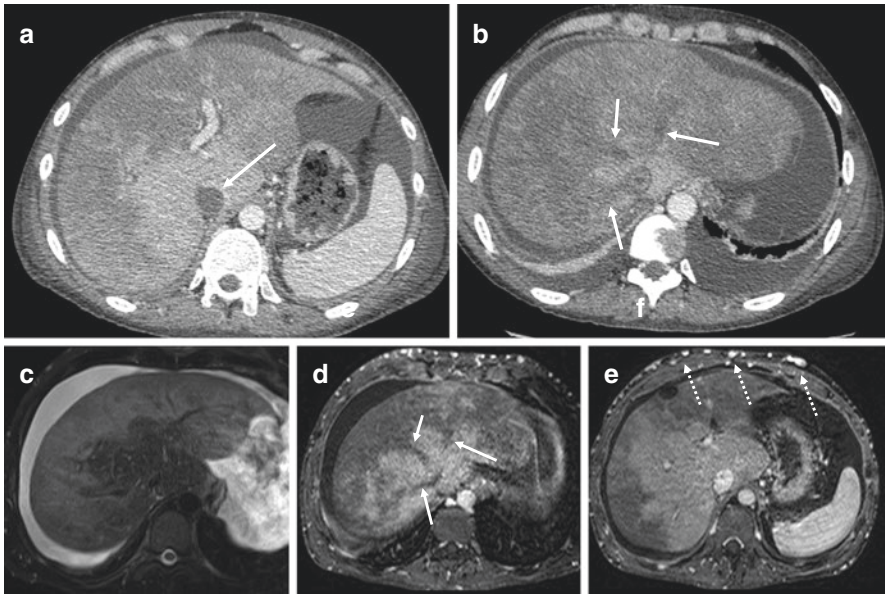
Acute Budd–Chiari syndrome with involvement of the inferior vena cava (IVC) in a 32-year-old female with myeloproliferative neoplasm. (a–b) Contrast-enhanced CT at portal venous phase shows thrombosis of the three hepatic veins (arrows in b) and of the retrohepatic IVC (arrow in a) as non-enhanced filling defect. CT also shows ascites and heterogeneous enhancement of the liver parenchyma, especially in the periphery. Note that the caudate lobe remains homogeneous. MRI performed 5 months later (c–e) shows persistent occlusion of the three hepatic veins (arrows in d) and of the end of the IVC. MRI also shows zonal perfusion visible as signal hyperintensity of peripheral liver parenchyma due to congestion on T2-weighted images (c), heterogeneous signal with a “mosaic enhancement pattern” while the caudate lobe shows preserved enhancement on contrast-enhanced images (d–e). Note the development of numerous parietal venous collaterals (dashed arrows in e) due to the occlusion of the IVC
